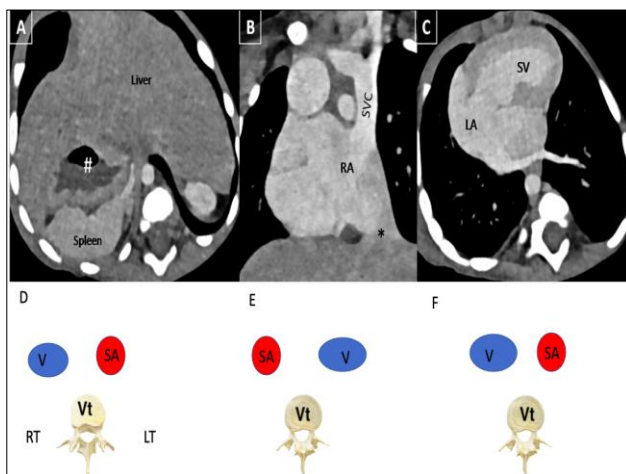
CT angiography images (A,B and C) showing situs inversus with liver on the left side, stomach (#) and spleen on right side, left sided superior (SVC) and inferior (*) vena cava with levocardia and single ventricle (SV) with ventricular apex towards left. The images D,E, and F are showing the relationship of superior mesenteric artery (SA) and superior mesenteric vein (V) in normal individuals, during malrotation in normal individuals and malrotation in situs inversus respectively. [LA=left atrium, Lt= left side, RA= right atrium, Rt= right side, Vt= Vertebra]
